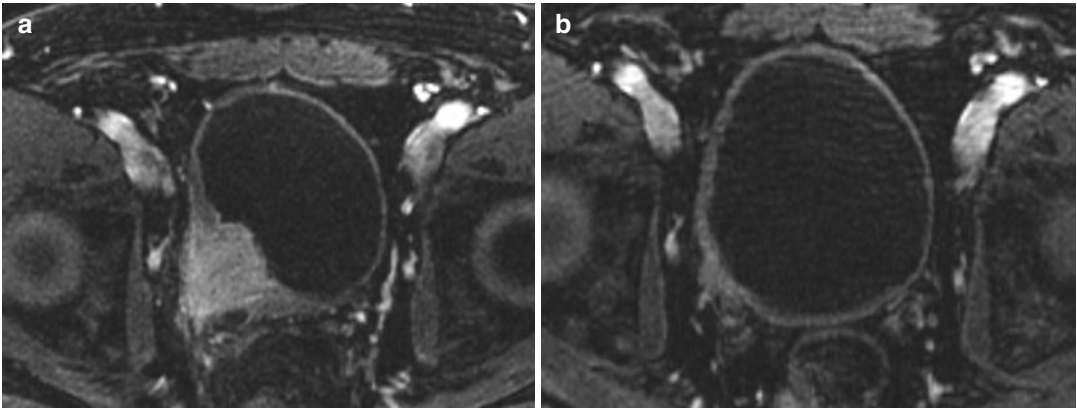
60-year-old man with muscle-invasive bladder cancer treated with neoadjuvant, dose dense MVAC. Baseline fat-saturated T1W post contrast MRI of the pelvis (a) demonstrates a mass at the right vesicoureteral junction extending through the wall of the bladder and into the perivesical fat (T3b). Right hydronephrosis
